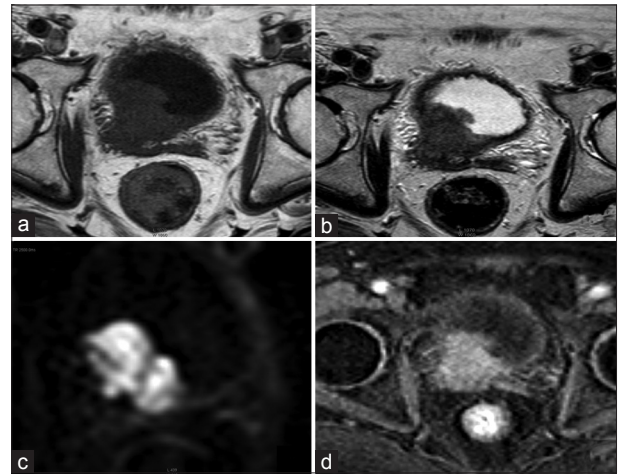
Stage 1 Grade 2 transitional cell carcinoma (a and b) T1- and T2-weighted image shows a single polypoidal intraluminal anterior wall mass (c) diffusion-weighted images a single polypoidal intraluminal anterior wall mass with diffusion restriction (d) dynamic contrast-enhanced imaging shows a single polypoidal intraluminal anterior wall mass showing intense enhancement
